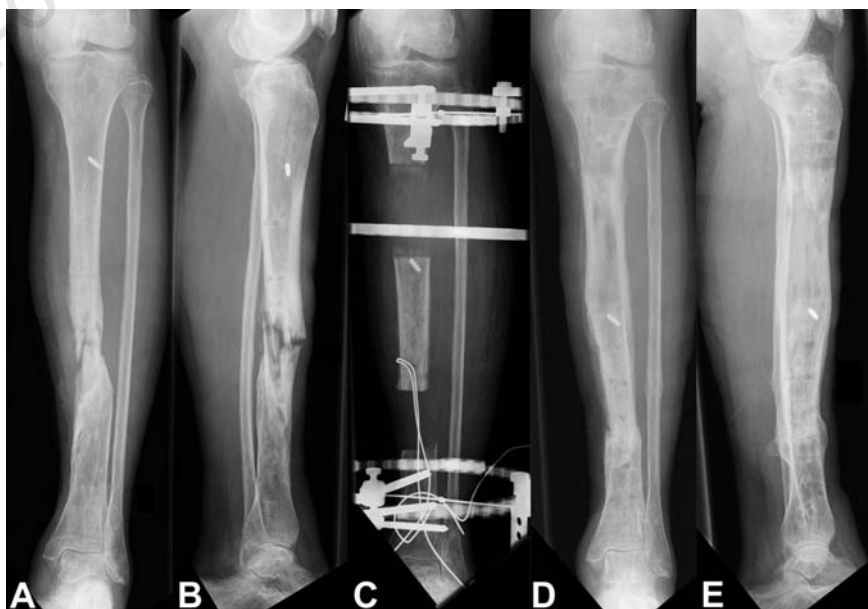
X-rays of Patient 8 with a pathologic fracture due to a chronic osteomyelitis at the day of admission (A, B) during transportation (C) and five months after frame removal (C, D, E).
